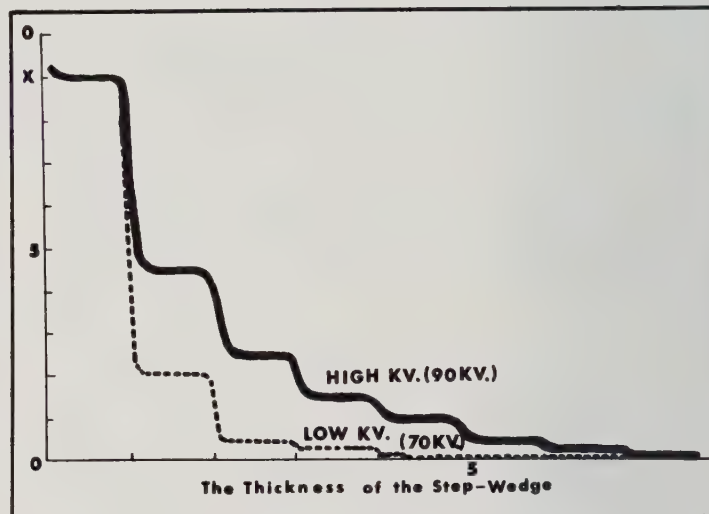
Densitometer scan of step wedge radiograph at 90 kV and 70 kV superimposed on identical background densities at X.
